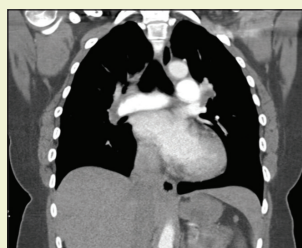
Coronal CTA showing clot present in both the left and right PA.
